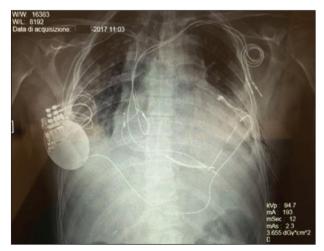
Chest X-ray postero-anterior (PA) view showing leads and ICD-CRT generator placement.
